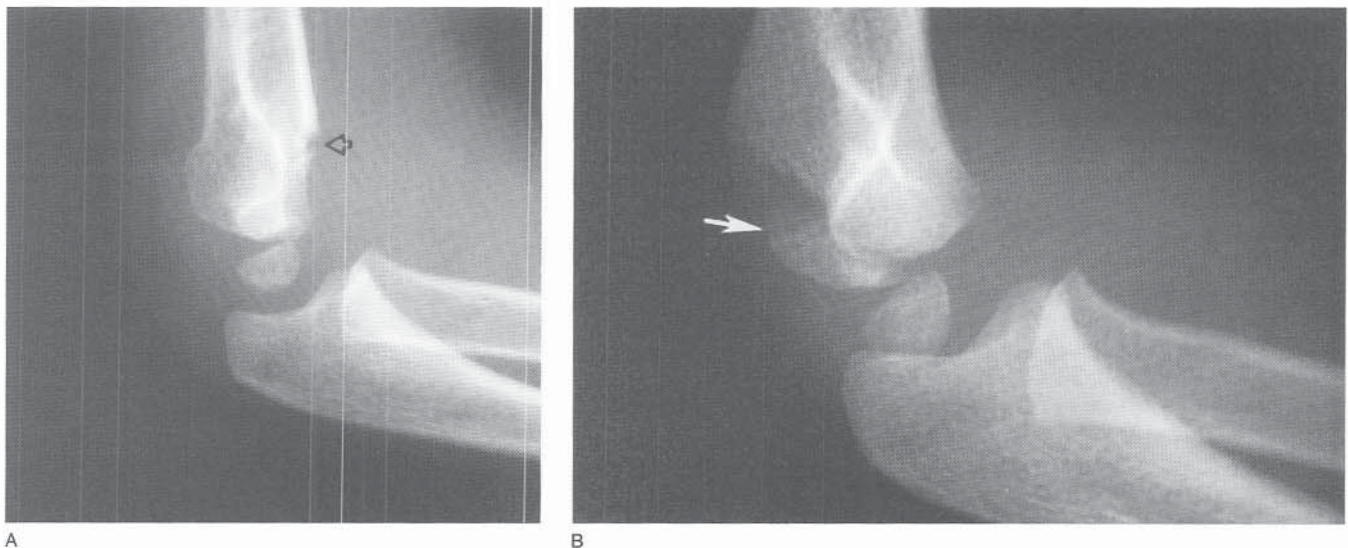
A, Lateral radiograph of a type II extension, supracondylar humeral fracture. The fracture originates just proximal to the “hourglass” of the olecranon fossa (open arrow). B, Lateral radiograph of a displaced lateral condylar fracture. The Thurston-Holland, or metaphyseal, fragment is at the posterior aspect of the metaphysis (arrow). The fracture originates distal to the “hourglass” of the olecranon fossa.
